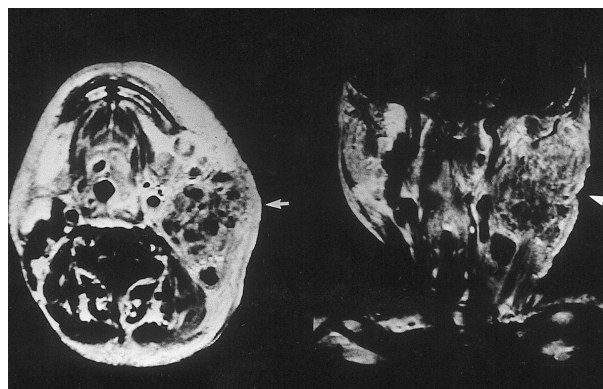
Magnetic resonance imaging (MRI) revealed a heterogeneously enhancing mass in the left parotid gland and multiple swollen lymph nodes in the left upper side of the neck, that had a mixed appearance of solid and cystic portion (horizontal section, left and coronary section, right).
